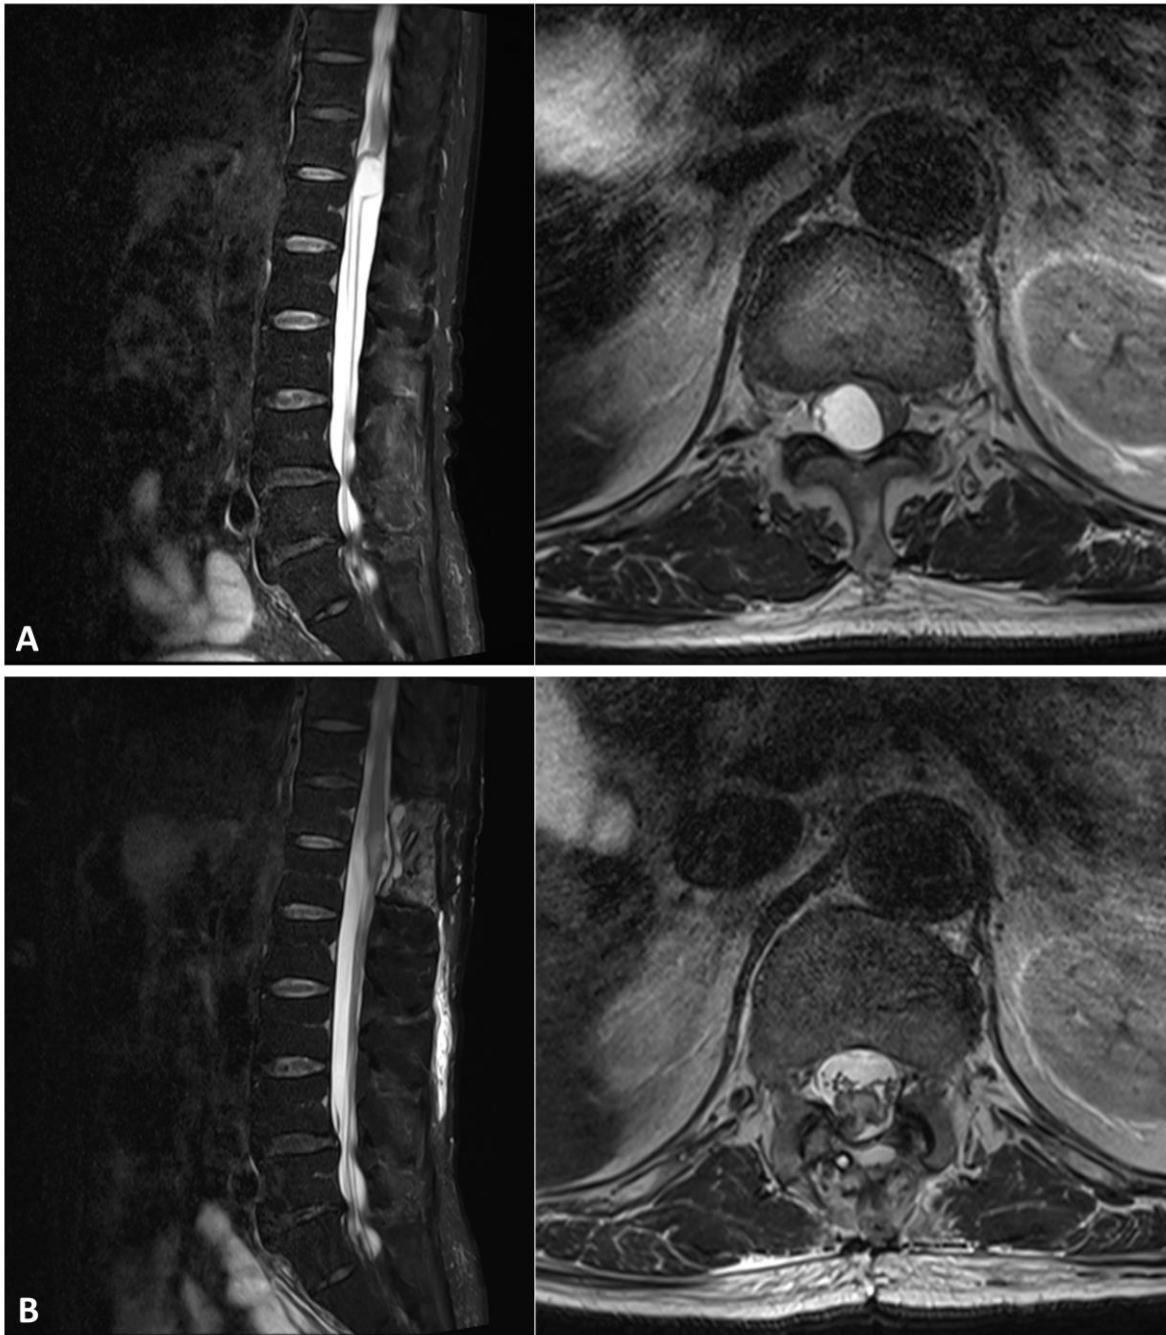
Magnetic resonance images of the spinal cord tumor before and after surgery. The T2-weighted magnetic resonance images before (A) and after (B) tumor removal surgery. The tumor was subtotally removed rather than en-bloc resection.
